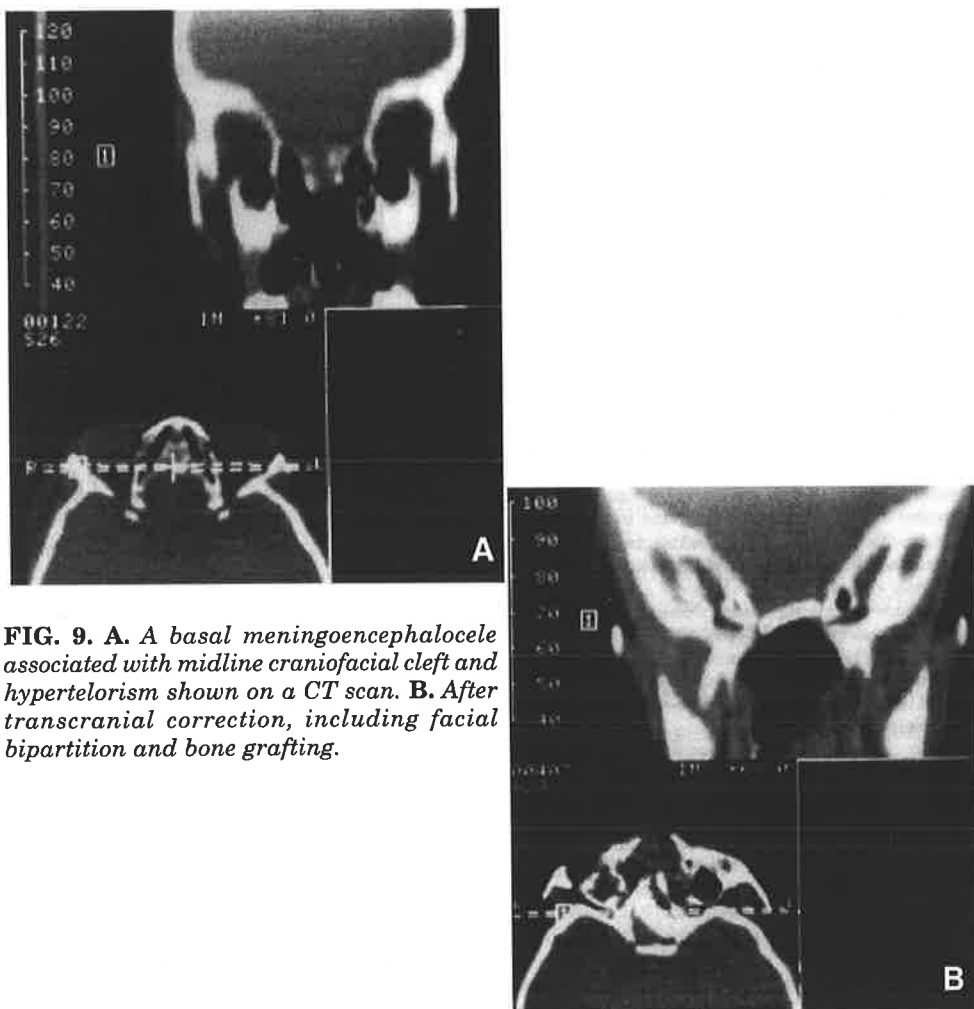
A. A basal meningoencephalocele associated with midline craniofacial cleft and hypertelorism shown on a CT scan. B. After transcranial correction, including facial bipartition and bone grafting.
